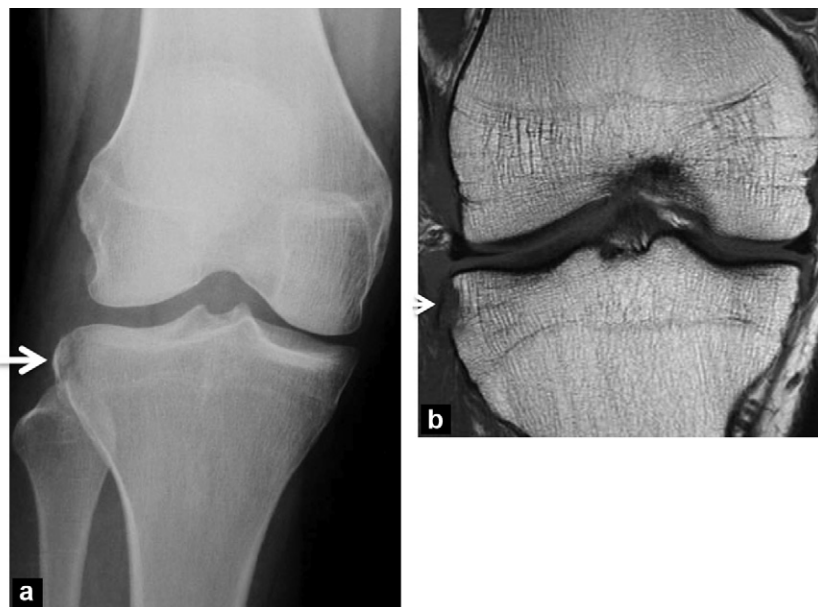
Second fracture, associated with a rupture of the anterior cruciate ligament (ACL) (not shown). a: front X-ray: bone fragment at the lateral edge of the lateral tibial plateau (arrow); b: MRI (coronal T1 weighted).
